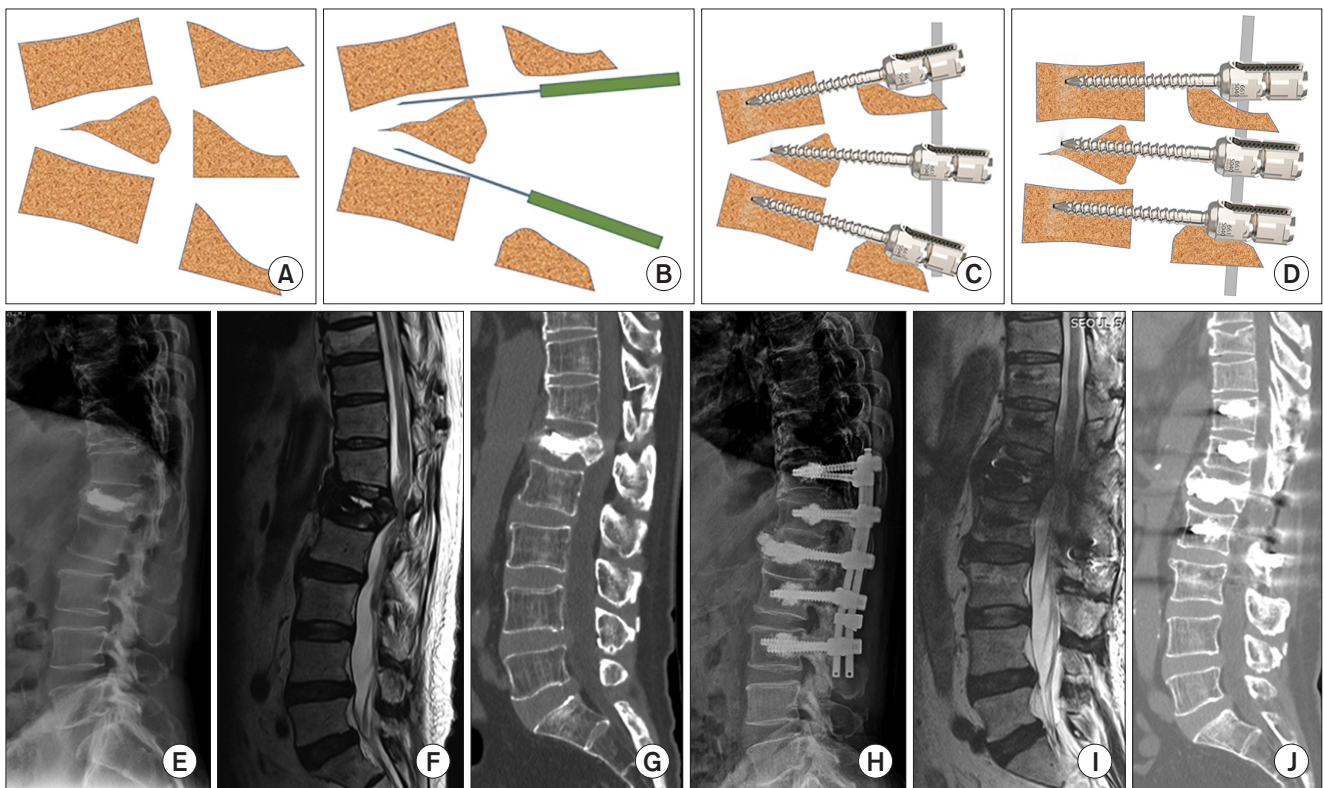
(A) The anterior part of the vertebral body is severely compressed and the posterior wall is extruded into the spinal canal with kyphotic deformity. (B) Posterior laminectomy is performed and adjoining discs are released. (C) Pedicle screws with different screw head heights are inserted. (D) While assembling a rod, the posterior cortex is pushed anteriorly to bear the compression force as the middle column and kyphosis is reduced. Preoperative plain radiograph (E), T2 sagittal magnetic resonance image (F), and computed tomography (G). Postoperative plain radiographs (H), T2 sagittal magnetic resonance image (I), and computed tomography (J) of the same patient.
